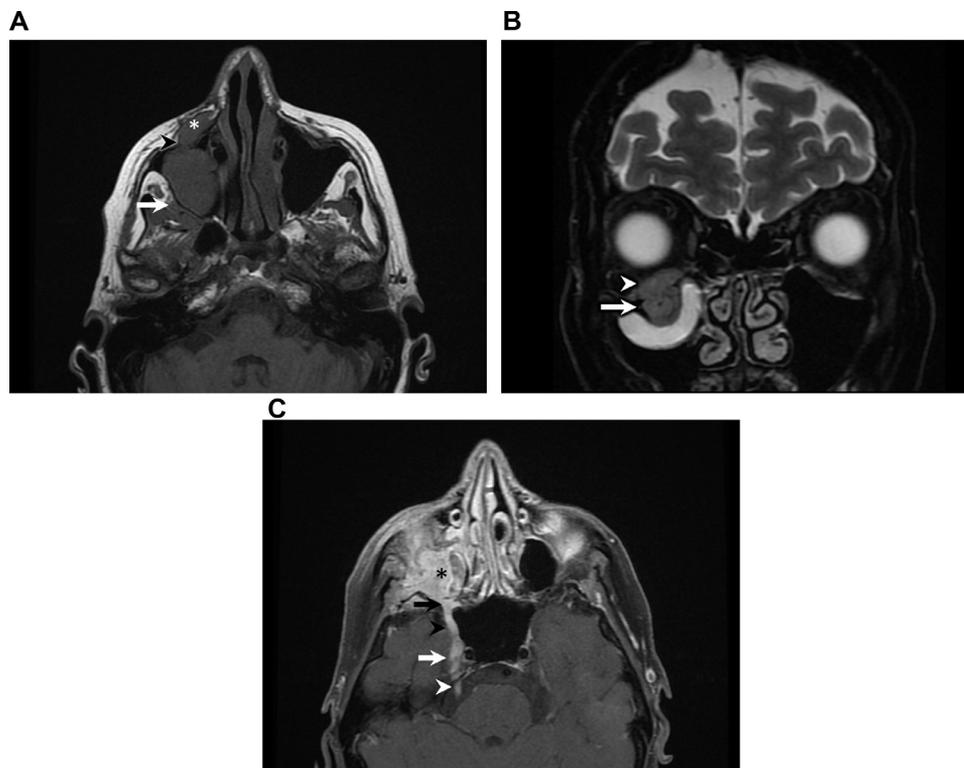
Extensive perineural spread of malignant melanoma in a patient with a palpable right facial mass. (A) Axial T1-weighted image demonstrates a mass in the right subcutaneous tissues (white asterisk) effacing the right infraorbital foramen (black arrowhead). Abnormal soft tissue replaces the right retroantral fat (white arrow) along the course of V2, raising suspicion for perineural spread of tumor. There is abnormal soft tissue opacifying the right maxillary sinus. (B) Coronal T2-weighted fat-saturated image. The tumor has T2 intermediate signal characteristics with extensive perineural spread of tumor along right V2, enlarging the right infraorbital nerve (arrow) and extending into the inferior right orbit (arrowhead). There is adjacent right maxillary sinus T2 hyperintense mucosal thickening. (C) Axial T1-weighted postcontrast fat-saturated image demonstrates enhancing tumor in the inferior right orbit (black asterisk) with perineural tumor spread involving right V2 in the right pterygopalatine fossa (black arrow), along widened foramen rotundum (black arrowhead) back to the Gasserian ganglion in Meckel's cave (white arrow) to the cisternal right fifth nerve (white arrowhead).
